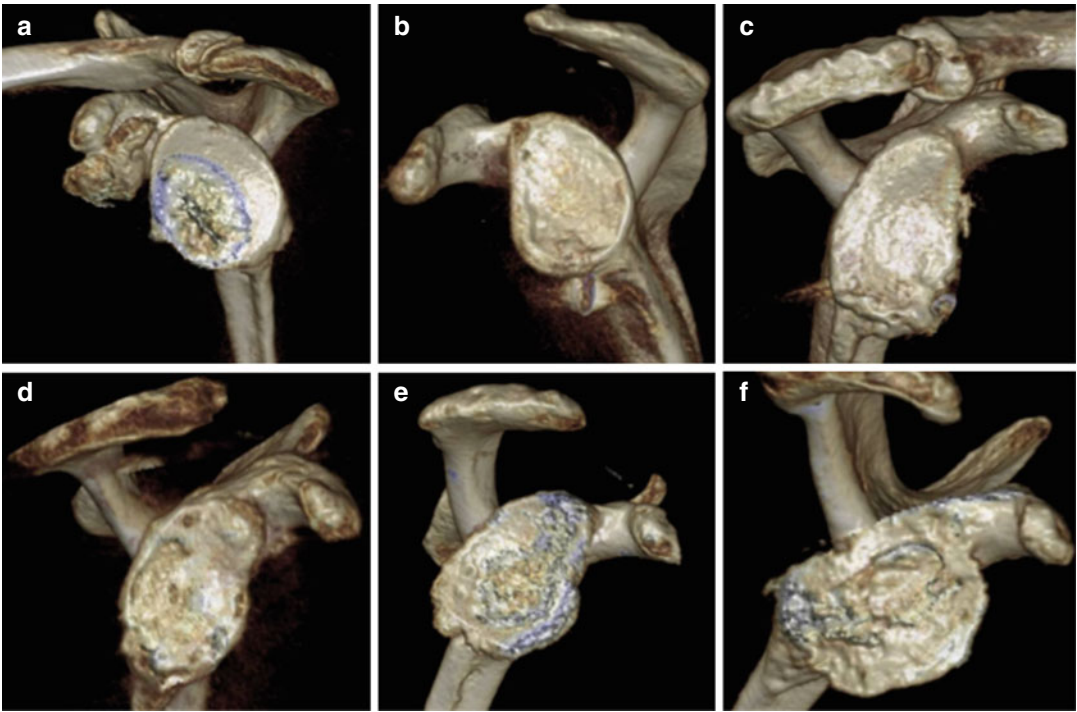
Glenoid shape* – variations in glenoid shape can be appreciated best by 3D CT reconstruction images. Osteophytes and wear patterns influence this shape. (a) Oval-shaped glenoid; (b) Pear-shaped glenoid with anterior-inferior osteophyte; (c–e). Pear-shaped glenoid with inferior osteophytes; (f) Posterior-superior glenoid wear alters the glenoid shape
